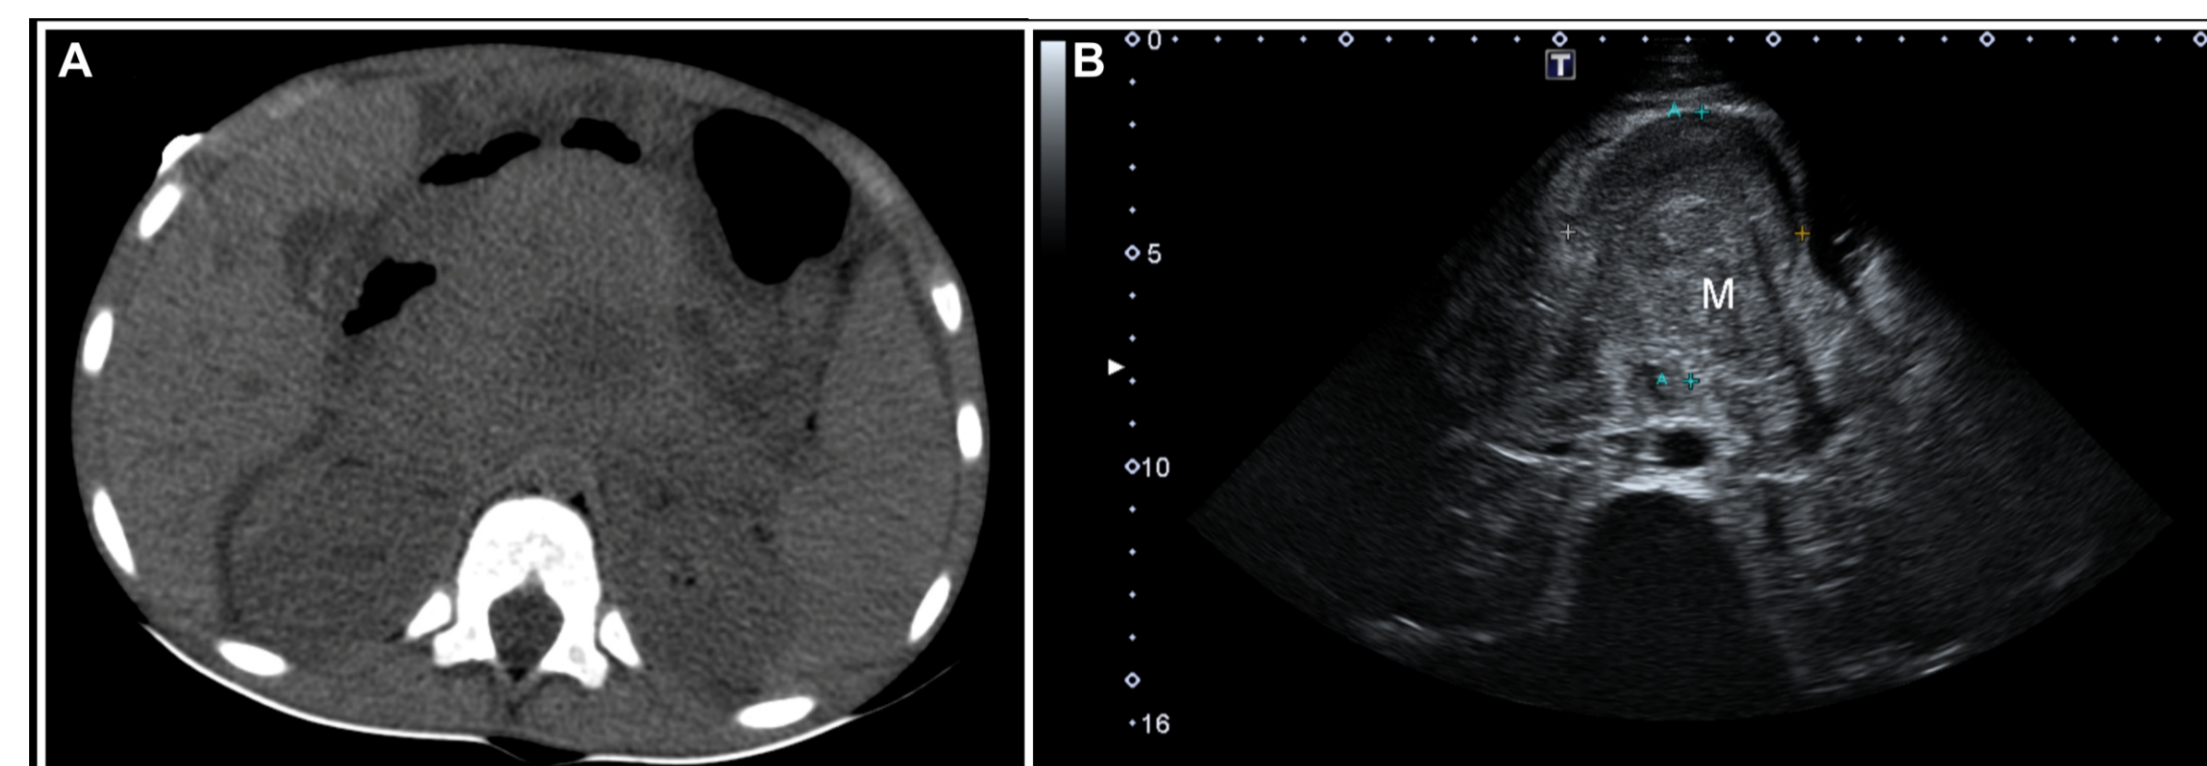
Clinical diagnostic data of MS and AML. A) Transverse focal CT image of the mesogastric region, acquired without contrast and with low ionizing irradiation, showing an expansive solid mass (M) on the midline with sharp margin definition and occupying the superior quadrants of the right mesogastrium. The mass extends through the hepatic hilum and the cleavage plane of the pancreas head. Li: liver; Sp: spleen. B) Ultrasonography image showing the extent (A+/+) of a solid mass (M: 7 cm \times 6.5 cm) with characteristics compatible with the CT image. RK: right kidney; Ao: aorta; IVC: inferior vena cava.
